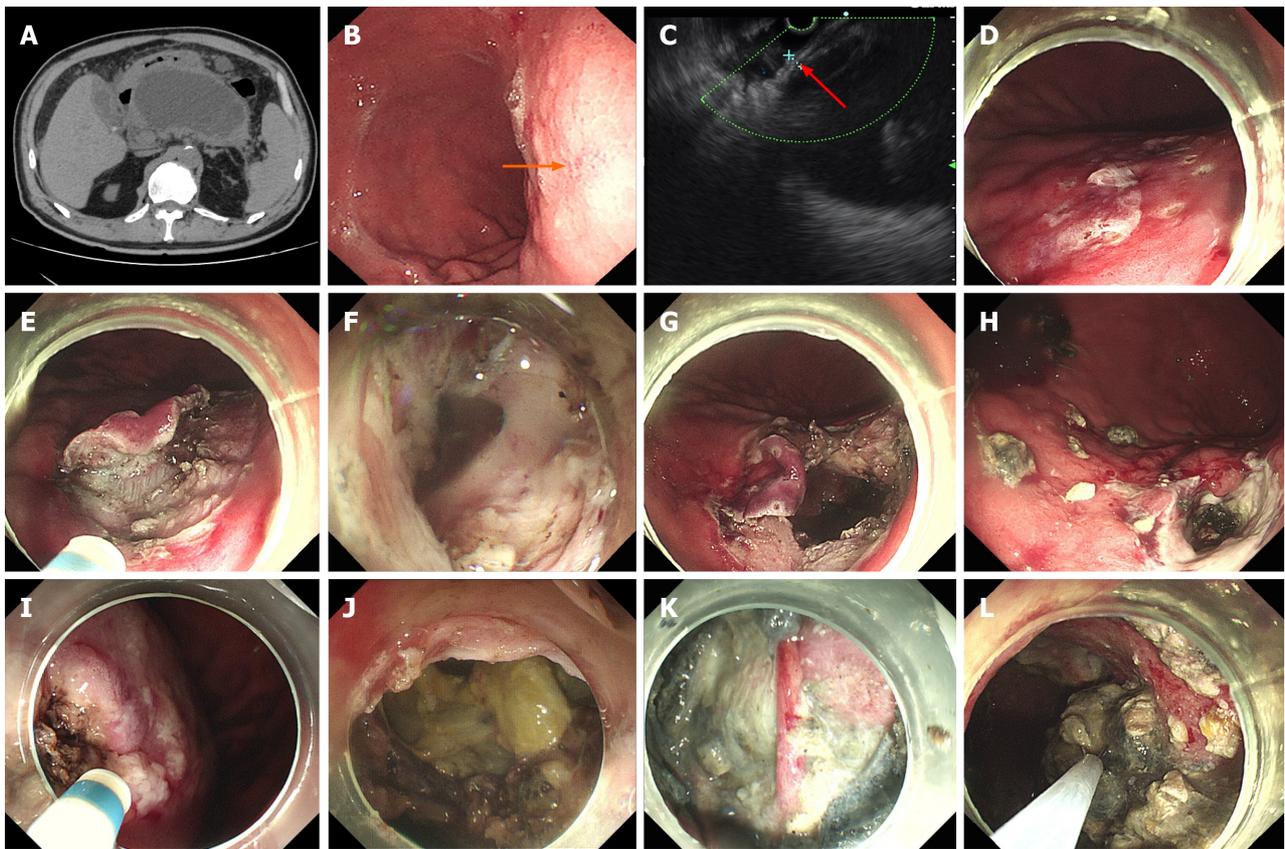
Endoscopic gastric fenestration technique. A: Closely connected walled-off necrosis (WON) and gastric wall lacking clear layers (black arrow, preoperative computed tomography scan); B: Compressive indentation of stomach by WON, with intense inflammation (orange arrow); C: Endoscopic ultrasound assessment and selection of fenestration site, abutment < 1 cm in combined thickness without clear layers (red arrow); D: Marking of prospective fenestration; E: Initial fenestration by endoscopic submucosal dissection; F: Penetration of WON capsule, releasing fluid content; G: Expanded fenestration; H: Self-healing of fenestration as seen by postoperative endoscopy (1 wk after endoscopic gastric fenestration); I: Narrowed area of initial fenestration; J: Enlarged expanded fenestration up to 3 cm; K: Necrotic tissue and exposed blood vessel in WON; L: Debridement of necrotic tissue.
